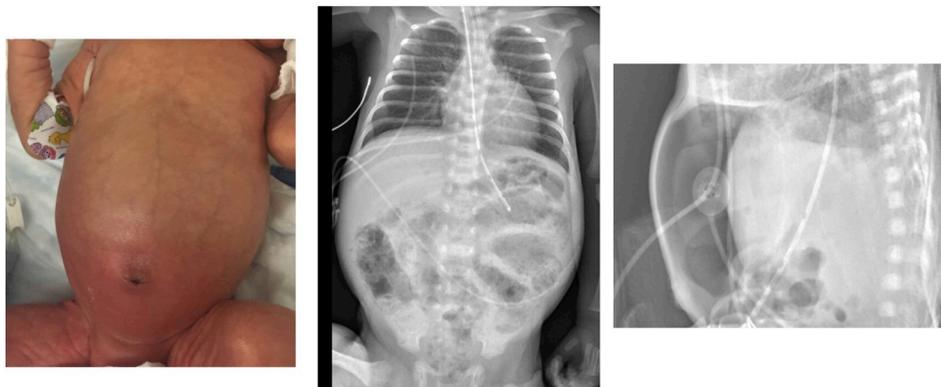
Clinical and radiographic findings of NEC. A - abdominal distention and discoloration; B - pneumatosis intestinalis; C pneumoperitoneum
